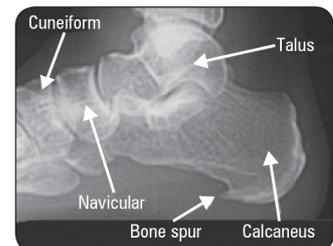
X-ray of bony heel spur
